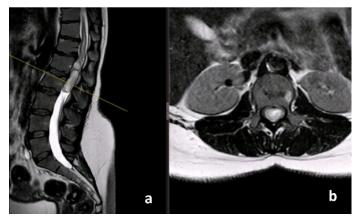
Massive lesion compatible with the epidermoid tumor in hyperintense heterogeneous internal structure at the level of the conus. T2 sagittal (a) and axial (b) section of lumbar MRI
